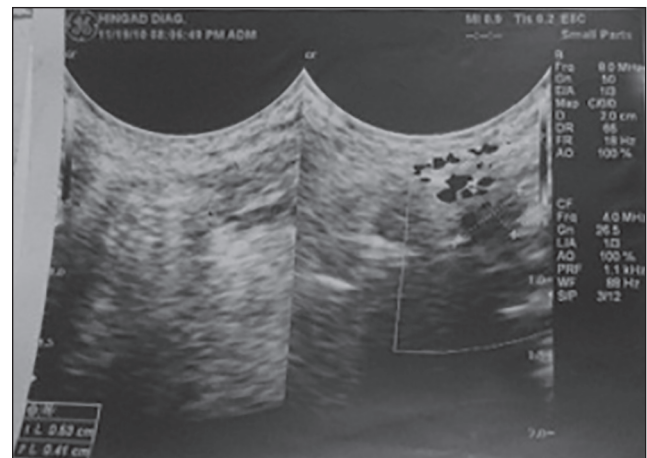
Ultra sonographic Image showing hypo echoic areas
